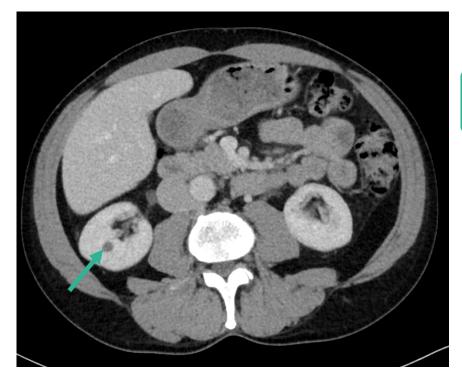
Pseudoenhancement. The axial images of a CT-scan of a patient with nasopharyngeal cancer show a simple, benign cyst of the right kidney. Measurement of the density showed 39 Hounsfield units. Additionally performed ultrasound showed a simple, Bosniak 1 cyst (see chapter on urogenital radiology). Thus the elevation of Hounsefield units can be evaluated as pseudoenhancement.
